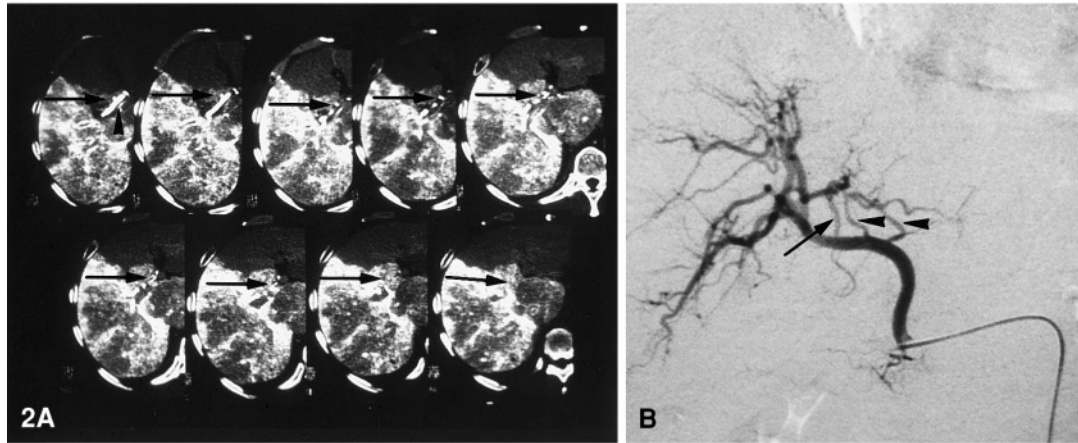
Blood supply from the main trunk of the right hepatic artery. A Caudocranial sequential slices (from upper left to lower right) of CT during right hepatic arteriography show opacification of the posterior aspect of segment IV and a tiny supplying artery (*arrows*) branching from the main trunk of the right hepatic artery (*arrowhead*). B Right hepatic arteriography shows the supplying artery directly branching out from the main trunk of the right hepatic artery (*arrow*). *Arrowheads* indicate the caudate artery.
